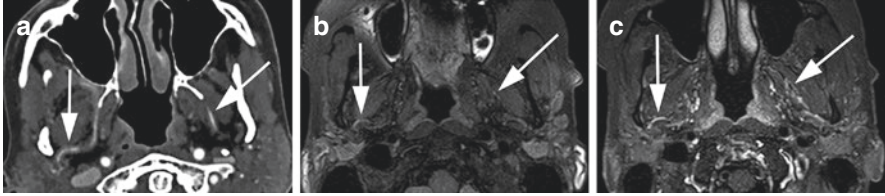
Internal maxillary artery vasculitis. Patient presenting with facial pain and found to have eosinophilic vasculitis on biopsy. CTA showed bilateral internal maxillary artery lumen narrowing and wall thickening (a, arrows). MRI also showed wall thickening on T1 precontrast black blood images (b, arrows) and enhancement on postcontrast images (c, arrows)
